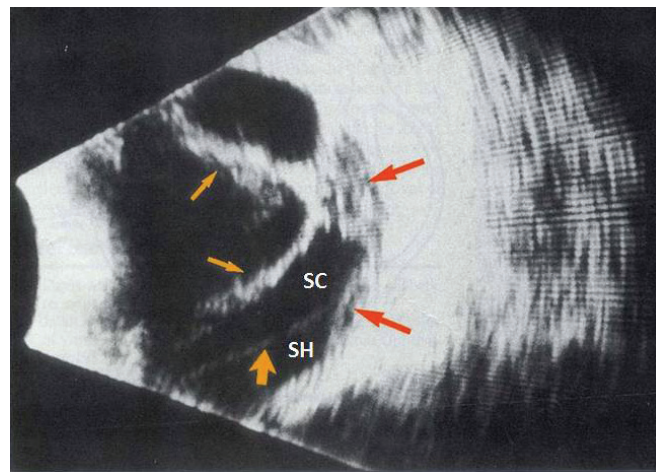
B scan ultrasonography picture showing vitreoschisis. SC- schisis cavity, SH- subhyaloid space, thinner yellow arrows – anterior leaf of vitreoschisis cavity (ALVC), thicker yellow arrow - posterior leaf of vitreoschisis cavity (PLVC), orange arrows – tractional retinal detachment.
